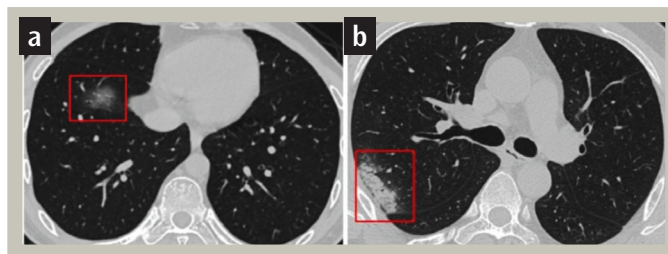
a) CT scan shows pure ground glass opacity in the right lower lobe (red frame). b) CT scan shows consolidation in the right lobe subpleural area (red frame) (9)
